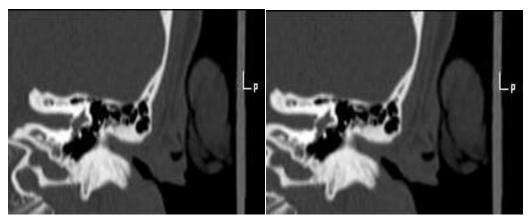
CT coronal reconstructed images of left ear shows soft tissue density lesion along entire length of bony canal sparing the cartilaginous external meatus. Middle ear appears normal.
